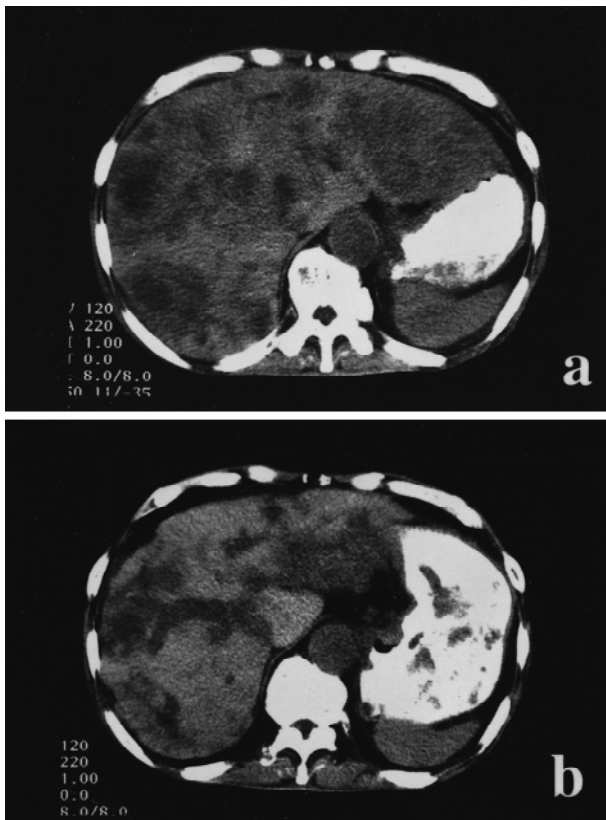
CT images of case 2 before (a) and after (b) hepatic arterial infusion. Multiple low-density areas were observed throughout the liver before hepatic arterial infusion (a), and they markedly decreased 5 months after initiation of the therapy (b)
